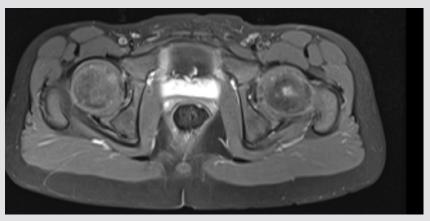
MRI study of the pelvis, axial T1 post contrast with fat saturation. Focal area of a decreased T1 signal with enhancement in the posterior aspect of the left lateral femoral condyle is shown.
